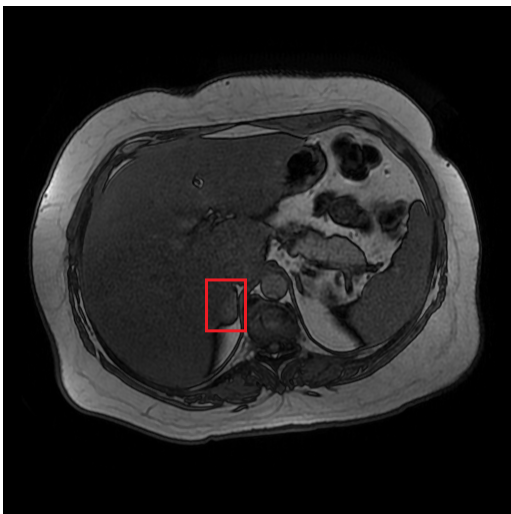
Normal adrenal glands in CT and MR slices. The arrows indicate the localization of the glands.
